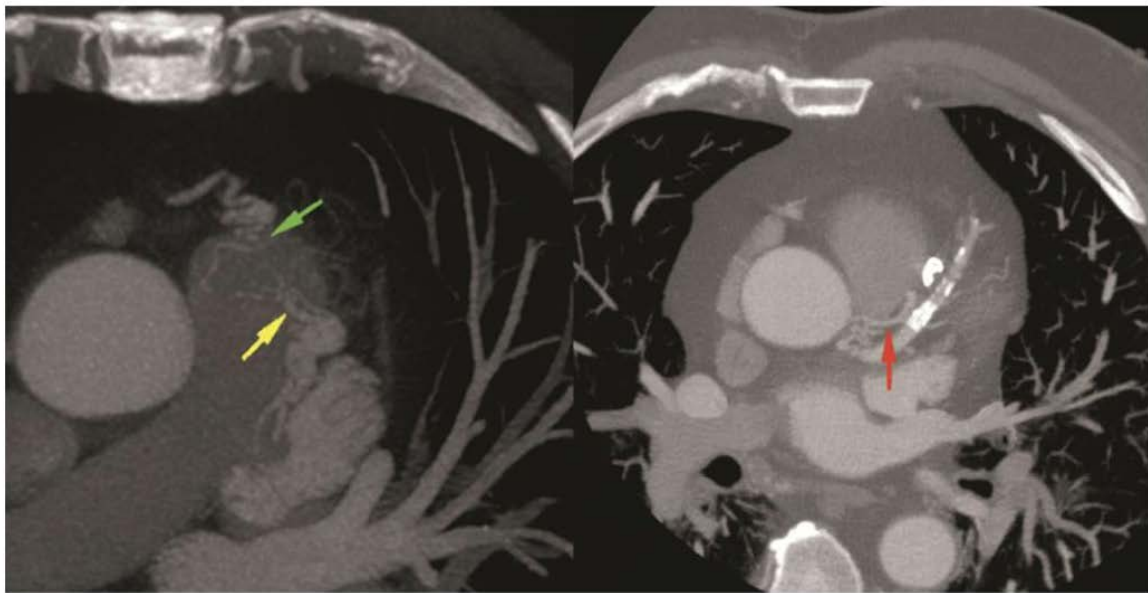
Cardiac computed tomography angiography images revealing: CAF draining into the PA axial MIP. A fistulous tract noted (green and yellow arrows) between LAD, conus branch and PA. The red arrow denotes a fistulous tract into the pulmonary artery from the left main coronary artery. Figure adapted and reprinted, with permission [90]. MIP, maximum intensity projection; LAD, left anterior descending artery.
